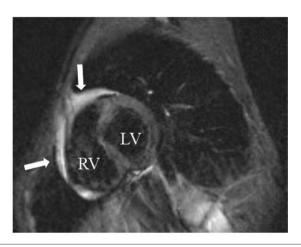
Cardiac magnetic resonance imaging performed in patient 1 showing normal finding but a small pericardial effusion in front of the right ventricle (arrows).
